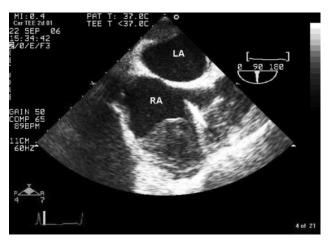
Transesophageal echocardiography bicaval view. Note the middensity mass in the right atrium. Biopsy forceps are seen within the mass.
